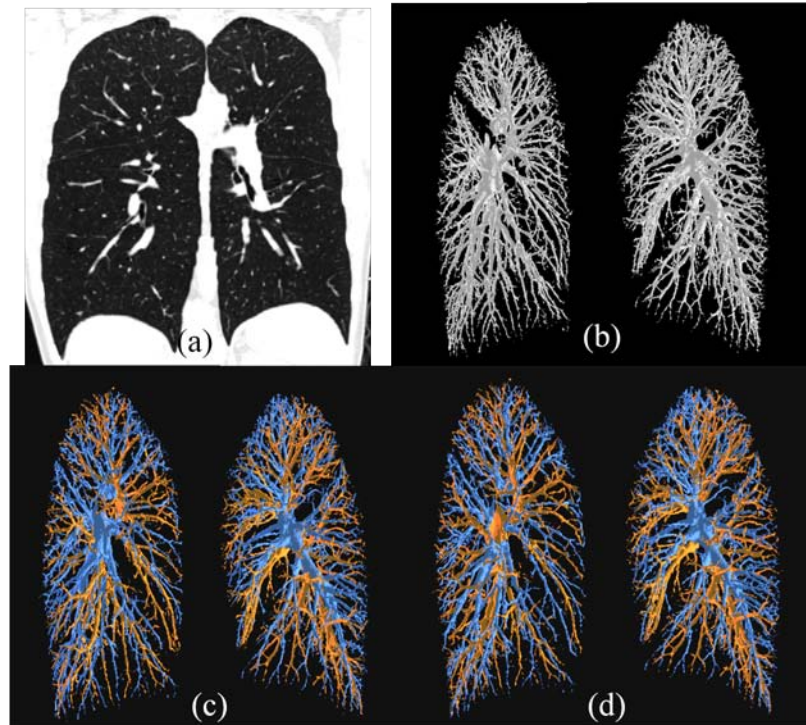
Results of A/V separation on an *in vivo* pulmonary CT image of a patient. (a) A coronal image slice from a thoracic CT image. (b) 3D rendition of the fuzzy segmentation of vasculature from the CT data. (c,d) Color-coded renditions of A/V separations using seeds selected by two independent experts.
